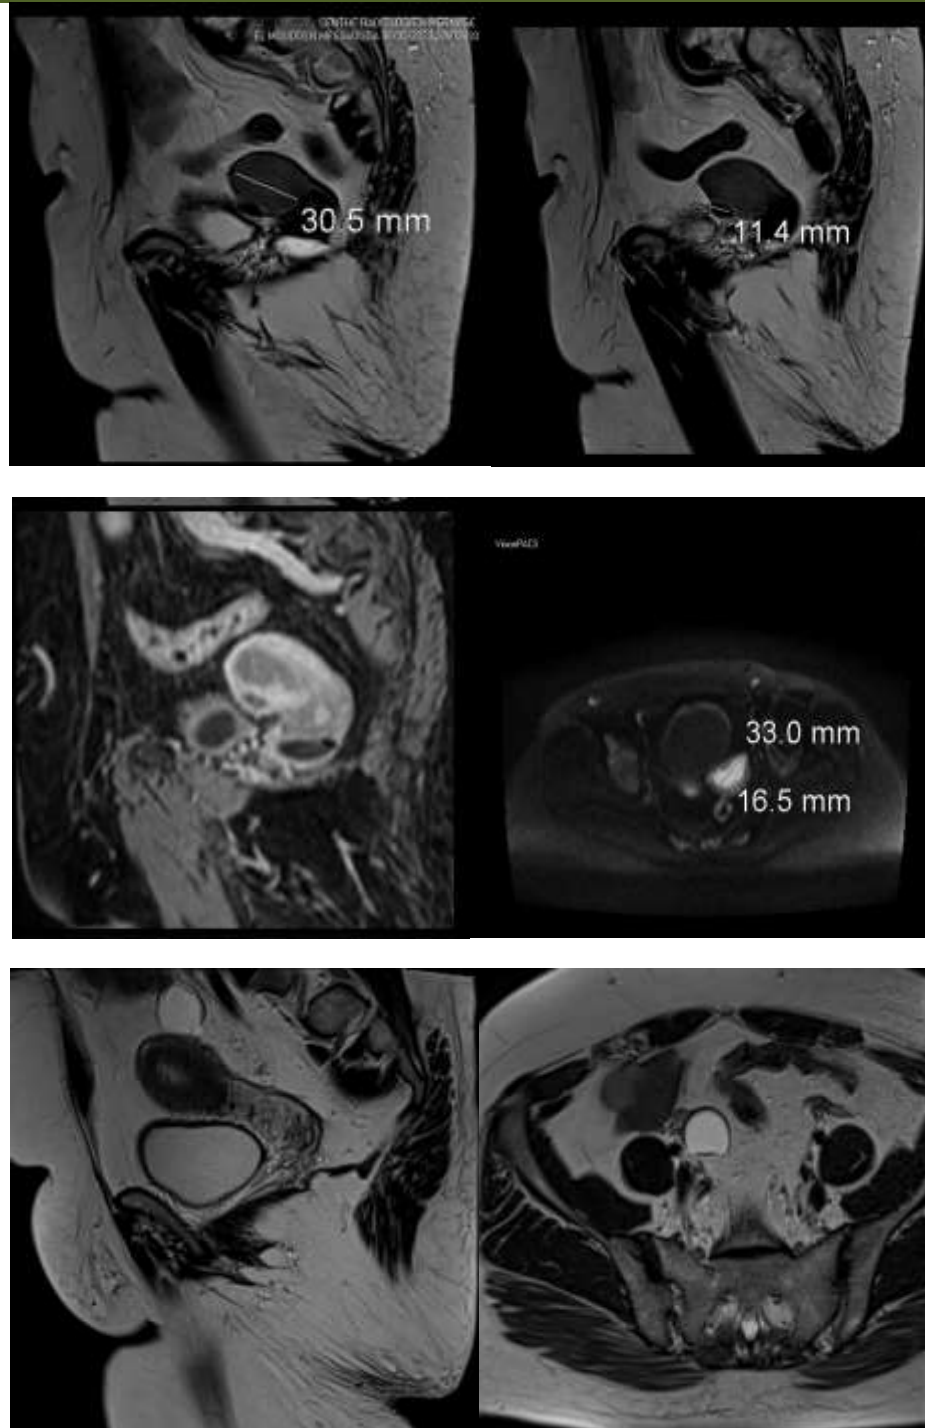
MRI of the pelvis showed a heterogeneously hypointense endometrium on T2-weighted imaging,s and mild enhancement post-contrast. No myometrial invasion was observed
